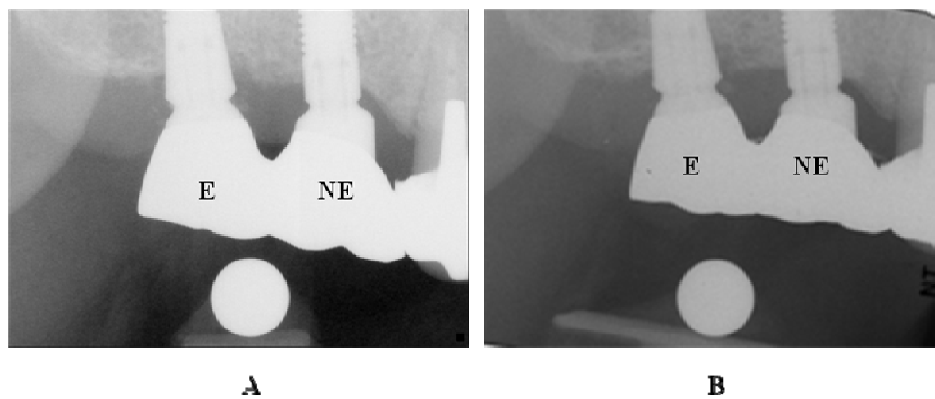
Intra-oral radiograph of implants
